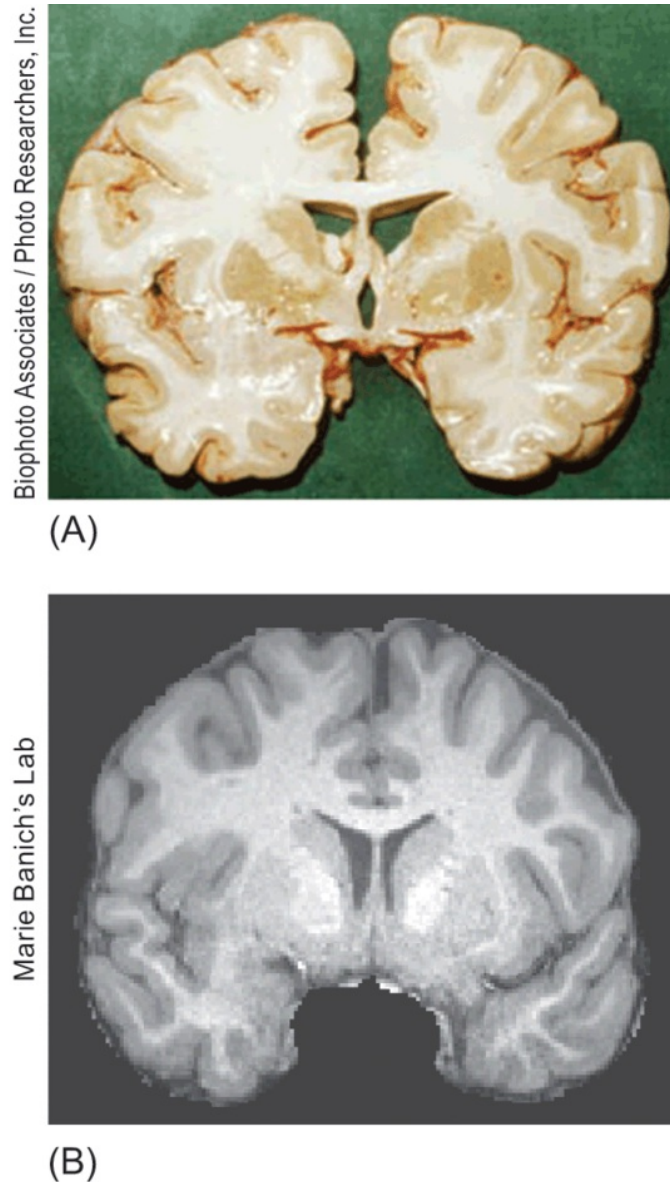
A comparison of the clarity obtained in anatomical dissection and magnetic resonance imaging (MRI).
